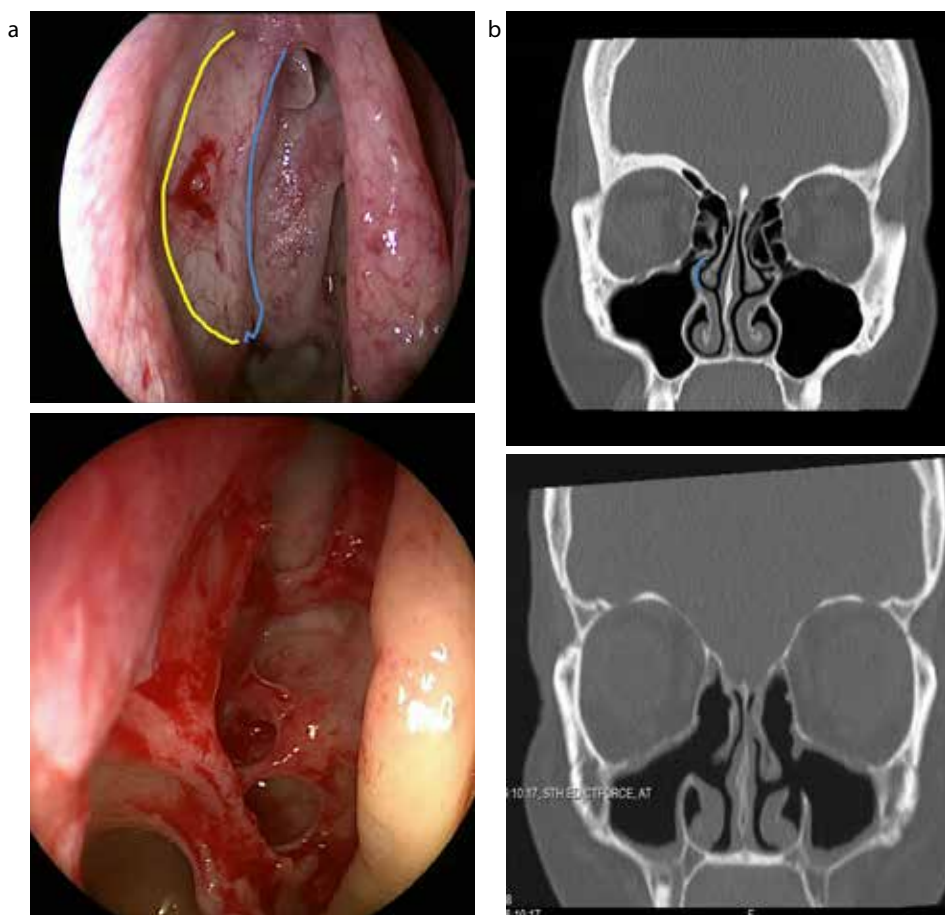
Pre-operative CT and endoscopy images. (a) The cleft between the free posterior margin of the uncinate process, marked in blue on the CT and outlined in blue on the endoscopy image below: the ethmoid bulla is known as the hiatus semilunaris, and is key to the drainage of the anterior ethmoid, maxillary and frontal sinuses. This common drainage pathway is called the ostiomeatal complex. During functional endoscopic sinus surgery, the uncinate is removed along its anterior margin (marked in yellow) to expose the maxillary sinus ostium and the ethmoidal bulla and partitions are removed to remove any obstruction to sinus drainage and allow topical access to the sinuses. (b) The post-operative CT shows the widely opened sinus cavities; on the endoscopic image the frontal recess (F) skull base and maxillary sinuses are exposed.
